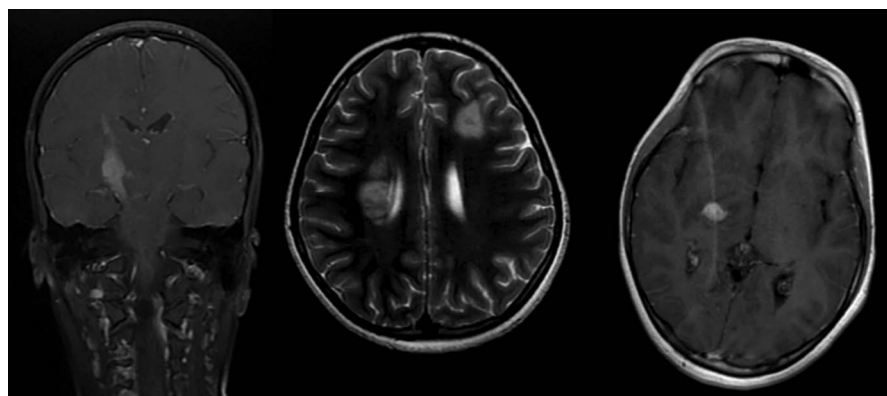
MRI showing acute demyelinating encephalomyelitis in a 12-year-old male
